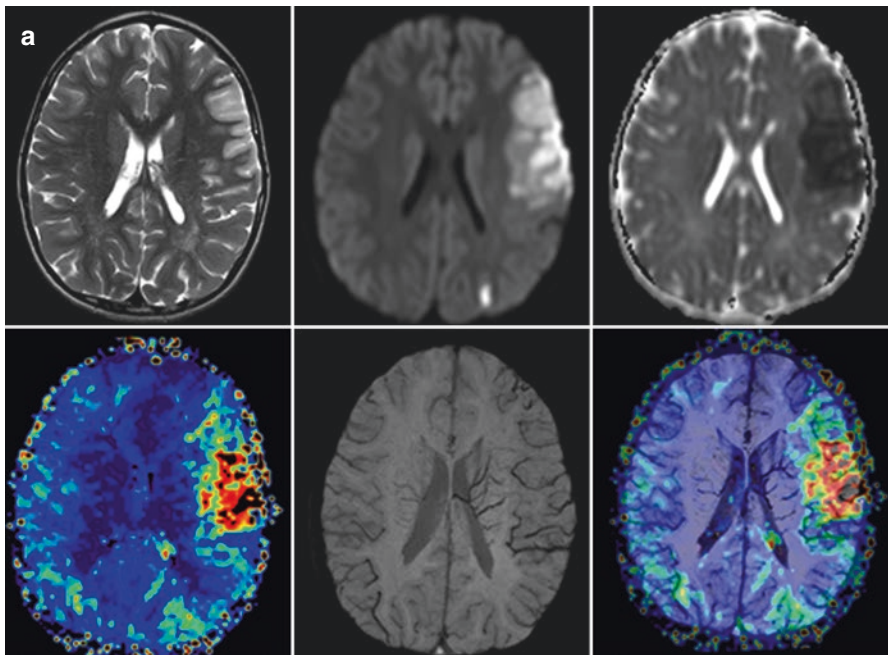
Six-year-old boy with right sided facial weakness, slurred speech and facial droop related to moyamoya vasculopathy. Multisequence anatomical and functional MRI (a) reveal a focal area of restricted diffusion (DWI-hyperintense, ADC-dark) with matching area of abnormal perfusion on perfusion weighted MR. The area of restricted diffusion is larger than the area of signal abnormality on the T2-weighted image. Prominent, SWI hypointense veins are noted to drain the ischemic tissue into the deep venous system. The SWI/PWI overlay image combines the information of PWI and SWI. Coronal and axial 3D TOF MRA images and conventional DSA (b) show the characteristic bilateral distal internal carotid artery occlusion with “moyamoya” collaterals along the expected course of the lenticulostriate arteries
